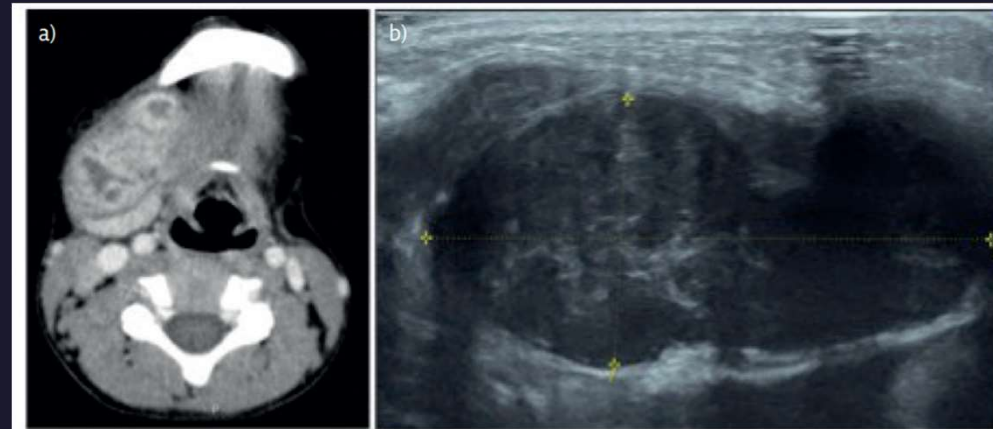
Tuberculous peripheral lymphadenitis imaging. Computed tomography scan and ultrasound of an 8-year-old
